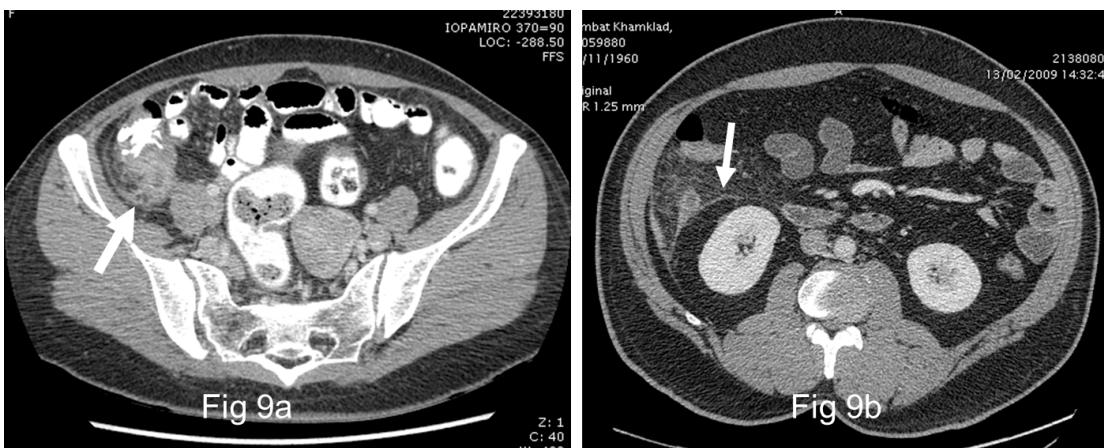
Axial enhanced CT scan of patient with acute gangrenous appendicitis, showed fluid-filled distension and enlargement of appendix with enhancing appendiceal wall, right lateroconal and right anterior pararenal fascial thickening (white arrow) and periappendiceal fat strandings.
